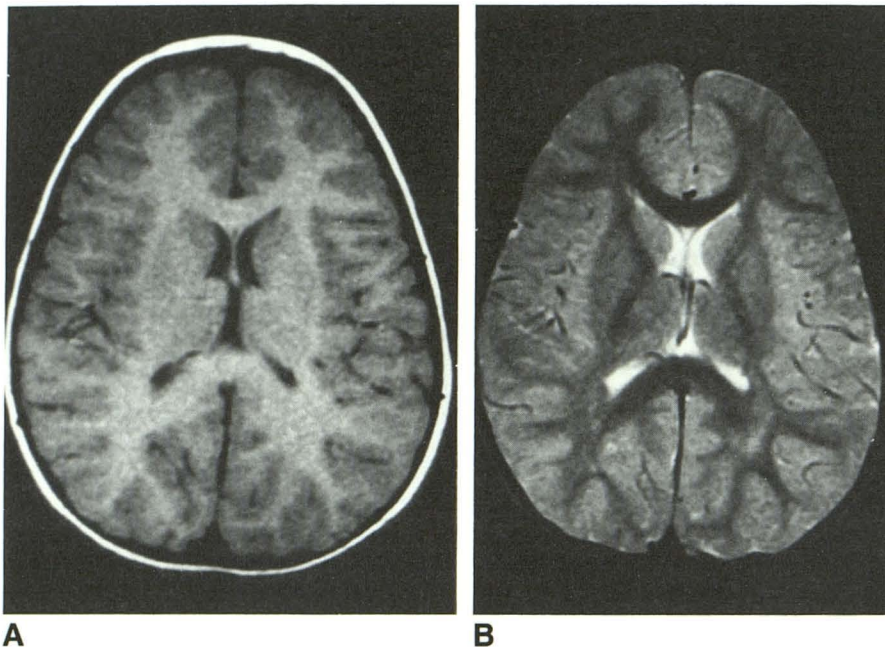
A and B, 2-year-old child. Axial T1-weighted, 600/20 (A) and T2-weighted, 2500/80 (B), images. On T1-weighted image the signal intensity of the genu and splenium of corpus callosum are similar to white matter in other areas. On the T2-weighted image these areas have lower relative signal intensity than any other white matter, which is partially related to their tightly packed axonal arrangement and, subsequently, to their smaller amount of interstitial water.
